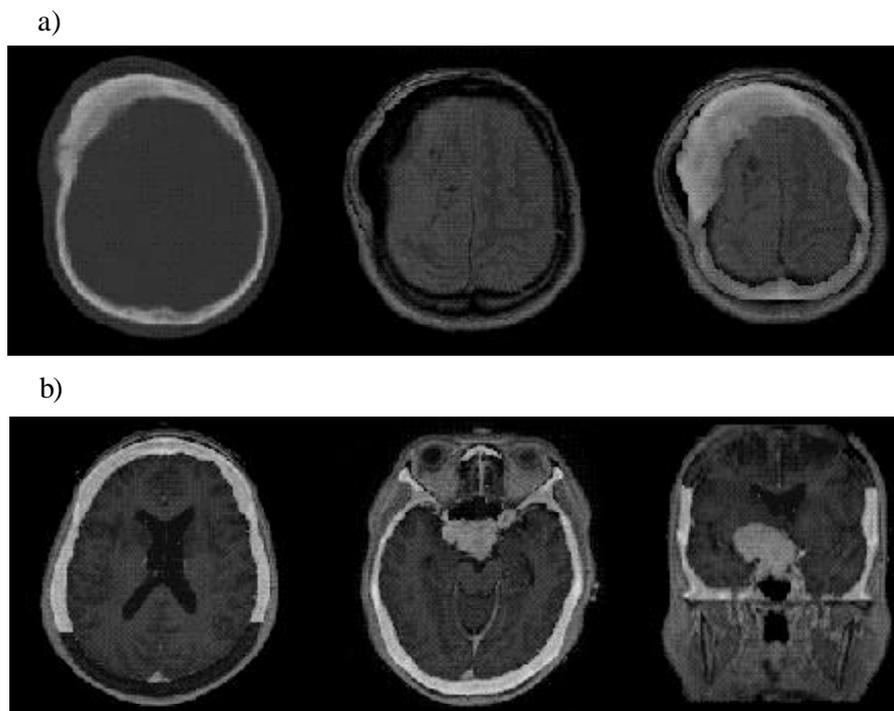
Registration of MRI and CT brain images in the presence of pathology: a) from left to right: CT, MRI, and fused axial images; b) axial and coronal fused images.
